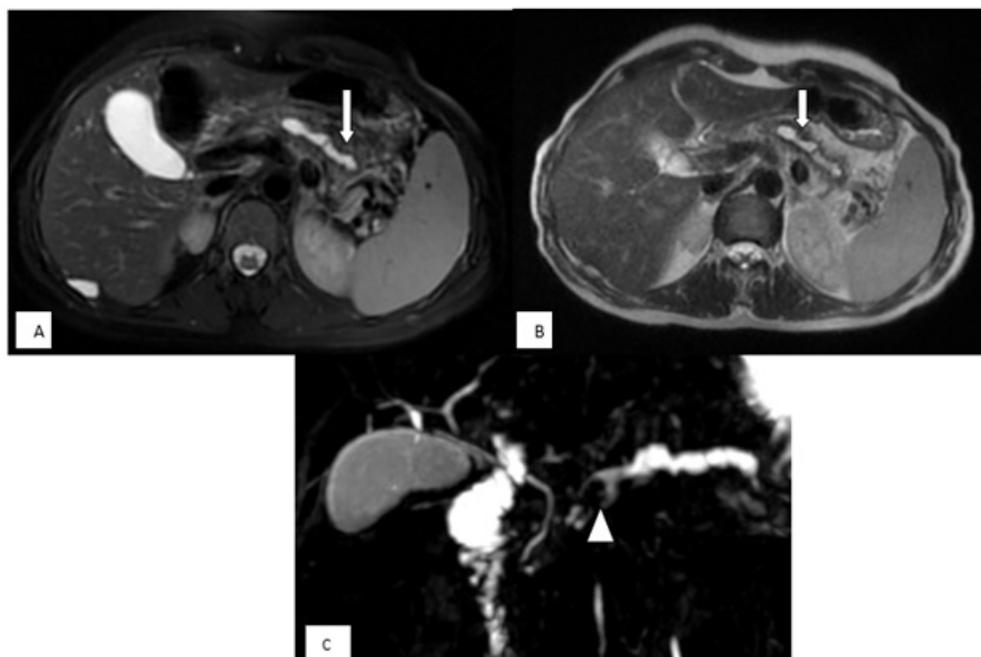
Pancreatic-MRI on axial T2-FS weighted sequence (A) and axial T2 weighted sequence (B) and 3D MRCP (C) showing a pancreatic atrophy (Arrow), non-uniform dilatation of the Wirsung upstream of an intraductal lithiasis (Arrowhead) and areas of signal void (intraparenchymal calcifications) (Short arrow).
